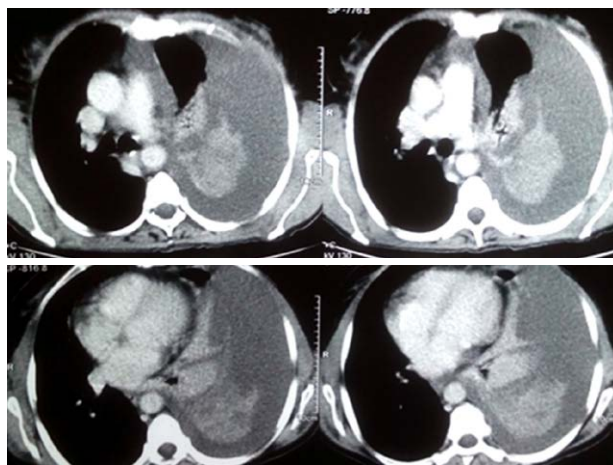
CT scan thorax- massive left sided pleural effusion with compression collapse left lung
